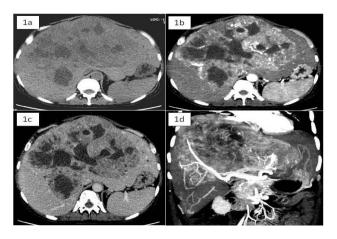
Axial images of triple phase computed tomograph scan of the abdomen revealing massive hepatomeagly with large hypodense; (1a) arterial enhancing hypervascular lesions with interspersed areas of necrosis involving both lobes of liver; (1b and c) Mip image; (1d) shows enlarged hepatic arteries supplying the hypervascular lesios with intense neovascularity (mip- maximum intensity projection).
